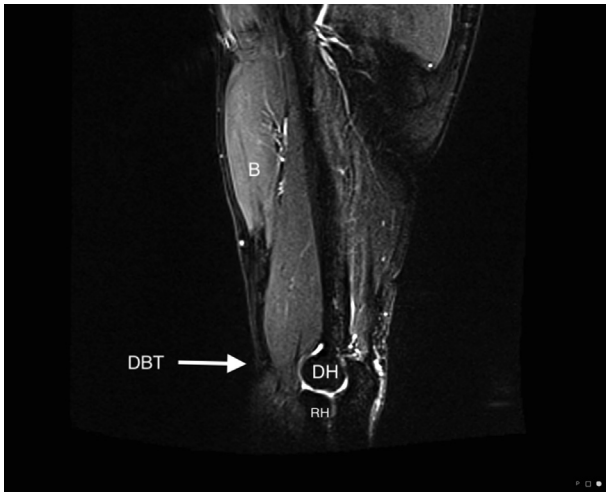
Preoperative MRI (T2 weighted, sagittal view) showing distal biceps tendon rupture and retraction. B, biceps muscle; DBT, retracted distal biceps tendon; DH, distal humerus; RH, radial head.
